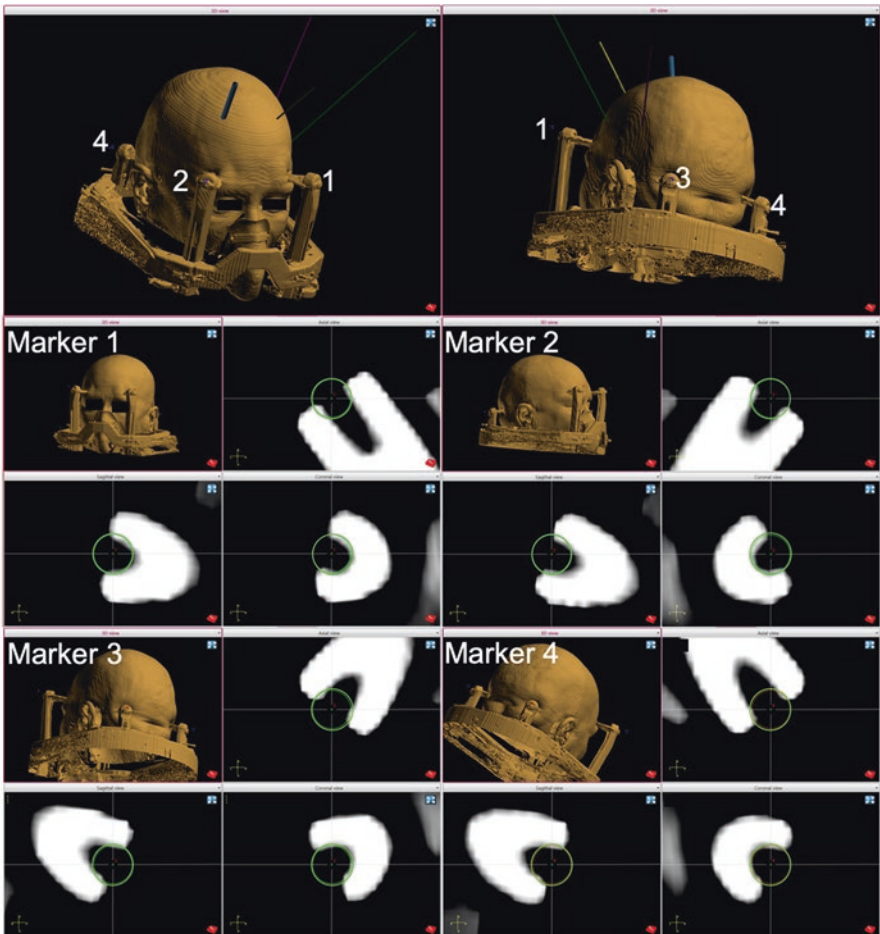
Setting fiducial points on the frame CT. For each of four registration points, the center of the titanium pin head is identified on the CT scan, and these locations are set as “marker” reference points (green circles) in the ROSA software. Figure reproduced from Faraji et al. [4]
